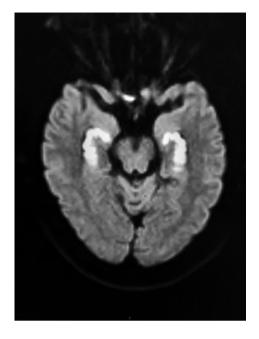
Bilateral hippocampal infarction after a hypoxic ischemic event. (Diffusion weighted MRI)
